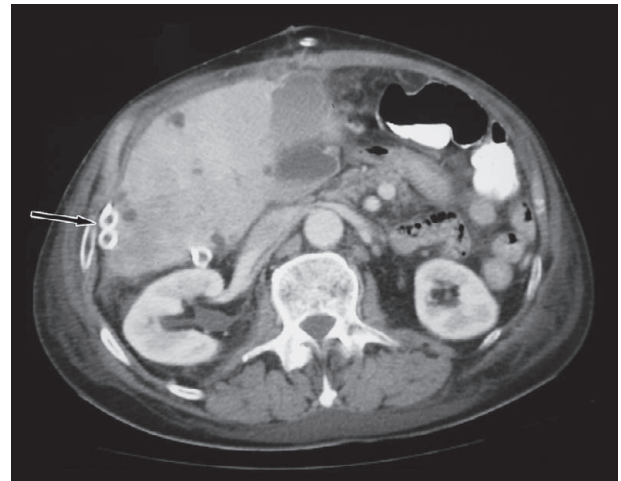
CT scan performed 7 days after operation. Visible a lesser hematoma in the site of previous hemangioma, as well as two abdominal drains, still placed in the perihepatic space (arrow).
